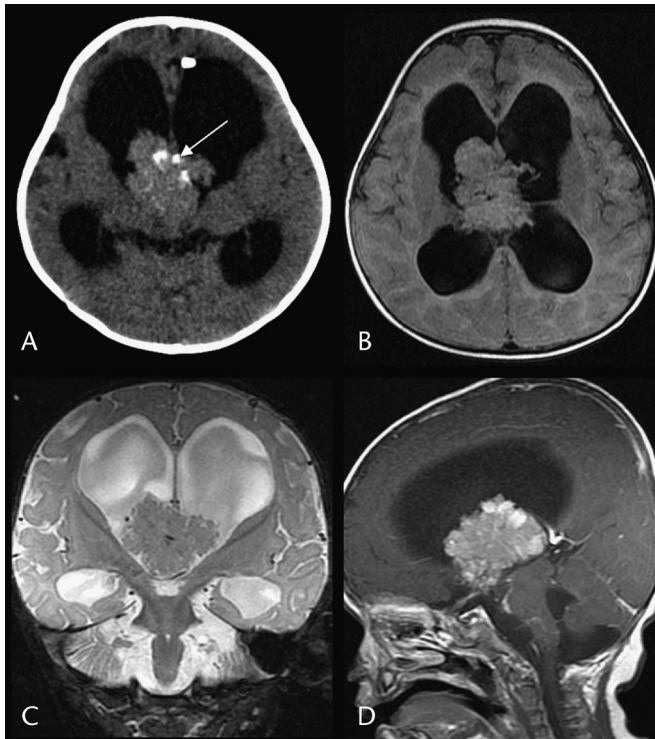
Choroid plexus papilloma in a 7-month-old girl. Noncontrast CT (A) shows a midline intraventricular mass with calcifications (arrow), enlarged ventricles, and a portion of the left frontal ventricular catheter. Axial T1 (B), coronal short τ inversion recovery (C), and sagittal postgadolinium T1 (D) images show the lobulated third ventricular mass that is isointense and markedly enhancing. There is extension through the foramina of Monro and marked lateral ventriculomegaly.
